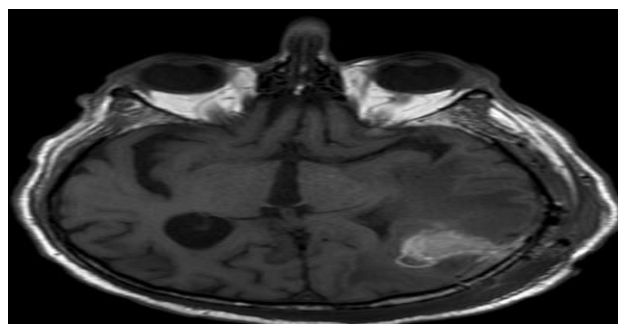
Brain MRI with abscess due to *Nocardia* in a diabetic patient.^[29]
